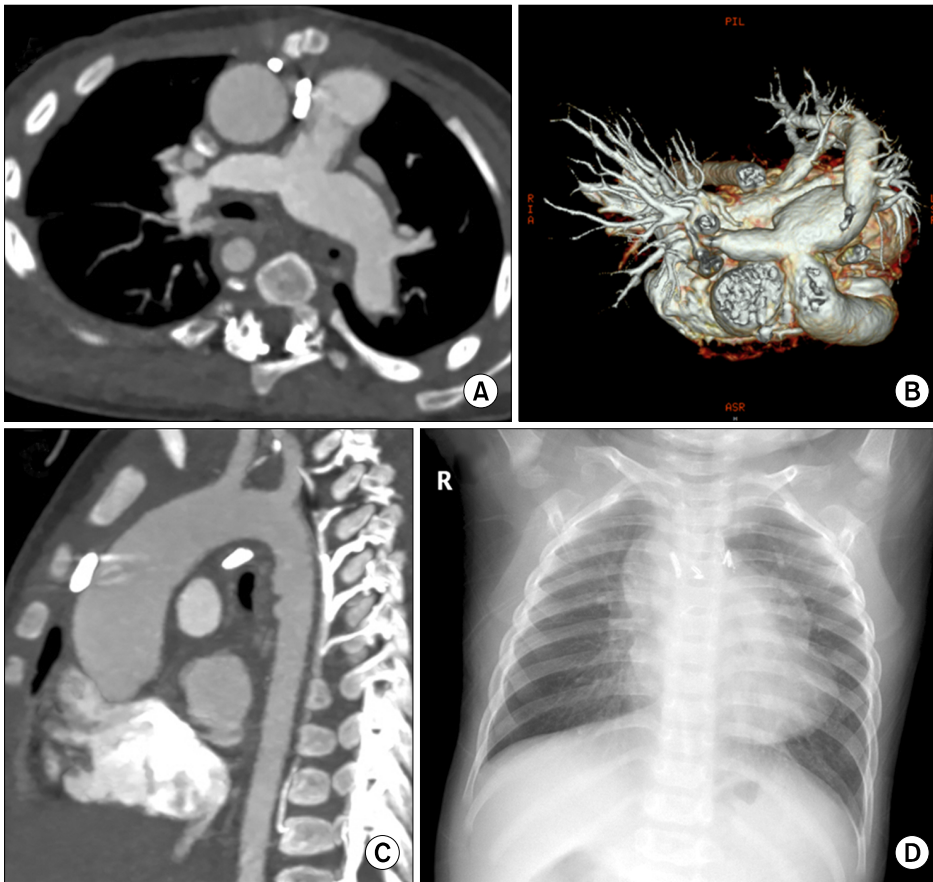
Follow-up heart CT at discharge and simple chest radiography on the latest follow-up. Figures A-C are the follow-up heart CT image at discharge. (A, B) The central right pulmonary artery and left pulmonary artery look widely patent. (C) Major aortopulmonary collateral arteries originating from descending thoracic aorta have disappeared. (D) Simple chest radiography obtained at the latest follow-up shows symmetrical and normal pulmonary vascularity, and prominent contour of ascending aorta and conduit between right ventricle and pulmonary artery. Otherwise, no remarkable findings are seen. CT, computed tomography.
